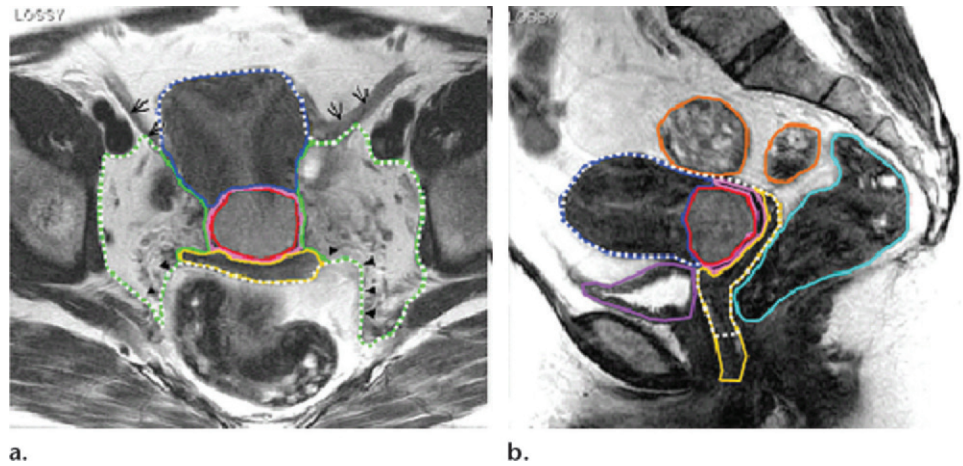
MR imaging–based target delineation in a woman with cervical cancer. Axial (a) and sagittal (b) MR images show that MR imaging–based planning allows contouring of the cervical tumor and GTV (red contour), cervix (pink contour), vagina (yellow contour), uterus (dark blue contour), parametria (green-dotted contour on a, aqua contour on b), bladder (purple contour on b), and large bowel (orange contour on b). Arrows on a point to the left and right broad ligaments, and arrowheads on a indicate the uterosacral ligaments and mesorectal fascia. (Reprinted, with permission, from reference 46.)
